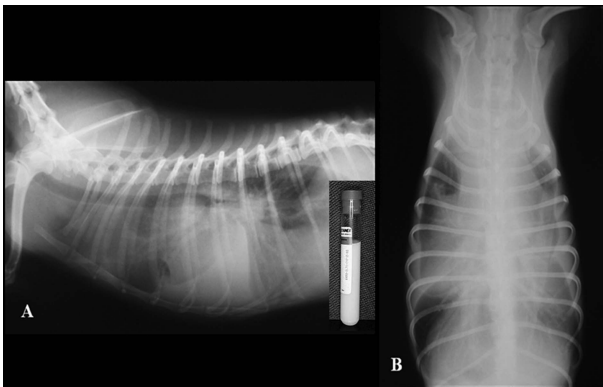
Lateral (A) and ventrodorsal (B) radiographs of a Case 1 with chyllothorax secondary to ASD. The inset in the right border of (A) picture shows milky and opaque pleural fluid. Note the loss of the cardiac and diaphragmatic silhouettes, and widened interlobar fissures.
